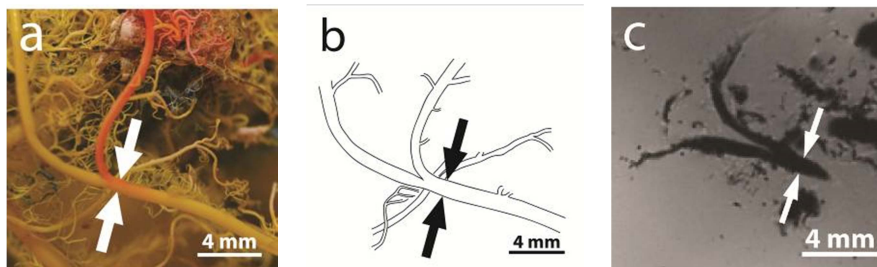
(a) Close-up of cast. (b) Sketch of same section as left image. (c) MRI of same section.
